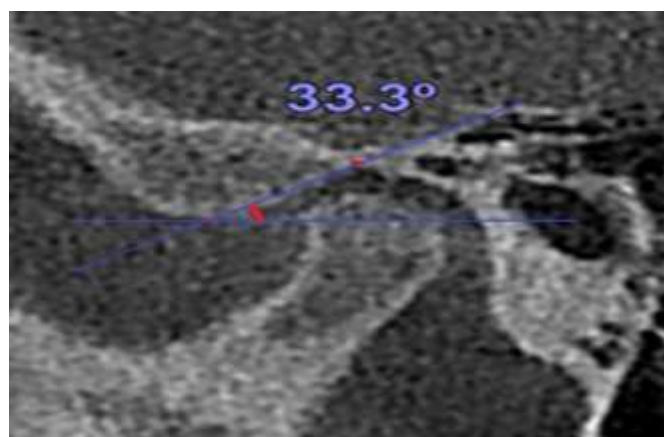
CBCT showed the measurements of articular eminence inclination (Top-roof line method).
